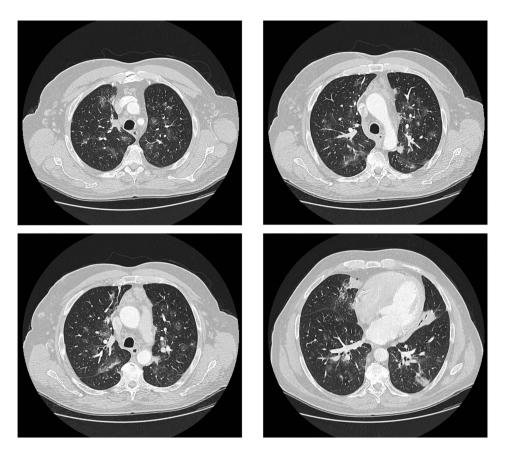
Computed tomography (CT) of the chest at presentation.
